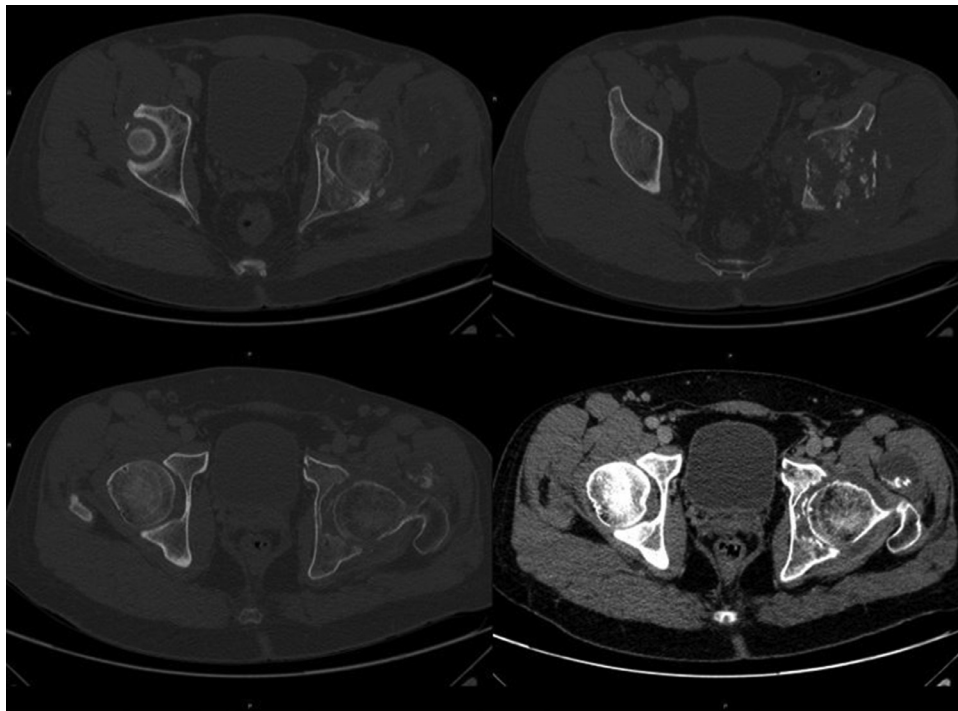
CT scan demonstrates a lytic process involving the acetabular region of the left hip and also shows extraosseous fluid/overfluid component with multiple contextual calcifications involving the gluteus minimus muscle and the ipsilateral internal obturator muscle.
